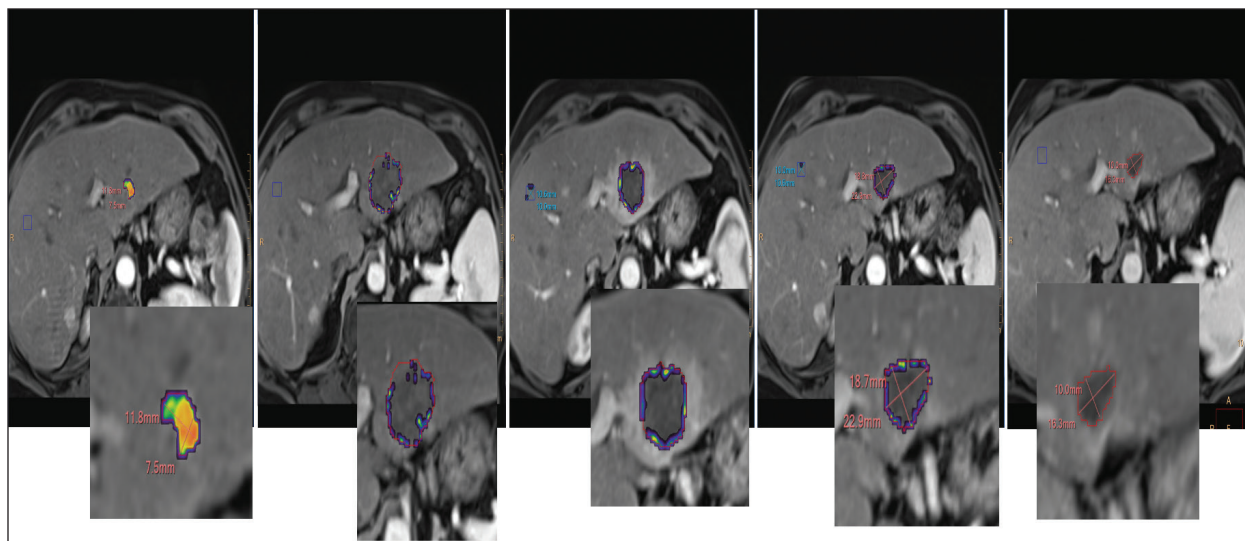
MRIs obtained at baseline and 24 hours, 1 week, 1 month, and 2 months posttreatment (from left to right) with histotripsy in a patient with a small hepatocellular carcinoma in segment 2/3. The three-dimensional measurement known as qEASL (quantifiable European Association for the Study of Liver) was performed using a semiautomatic tumor segmentation software (Philips Healthcare). The qEASL color map is overlaid on the subtracted MRI, showing the enhancing portions of the tumor in red/yellow before treatment and complete lack of enhancement after treatment consistent with a complete response to histotripsy (bottom row images are magnified views of the MRIs in the top row).
